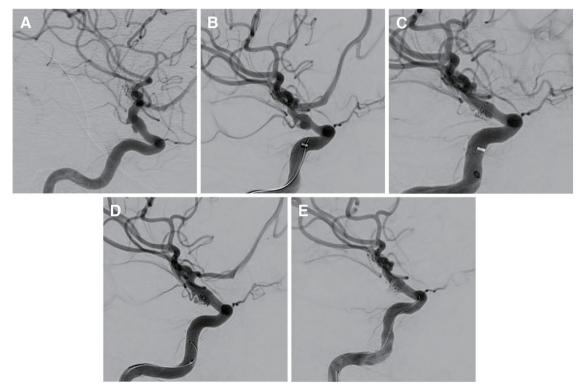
Case 4. A 42-year-old female. She was transported to our hospital owing to a sudden headache and vomiting. CT revealed SAH. (A) BBA was revealed on the right ICA C2 portion on day 1. We planned to wait during the acute phase and perform SAC during the subacute phase. (B) Rebleeding occurred on day 11. BBA size increased on DSA. (C) SAC was performed on the same day. (D) Rebleeding occurred again on day 18, and the aneurysm relapsed. (E) SAC was performed using the trans-cell technique. BBA: blood blister-like aneurysm, ICA: internal carotid artery; SAC: stent-assisted coiling; SAH: subarach-noid hemorrhage
